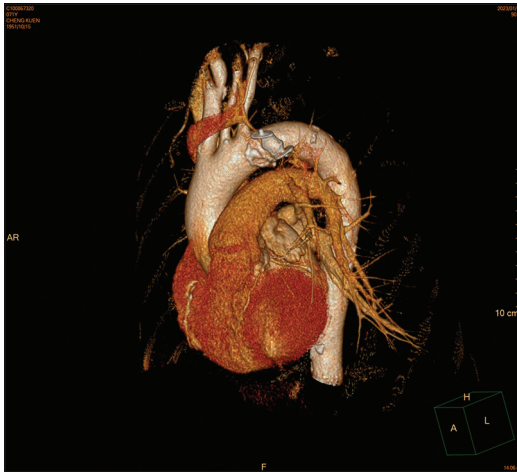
A follow-up contrast-enhanced computed tomography, conducted 8 months later, demonstrated a favorable position without any impingement on any structure and total occlusion of the vertical vein
